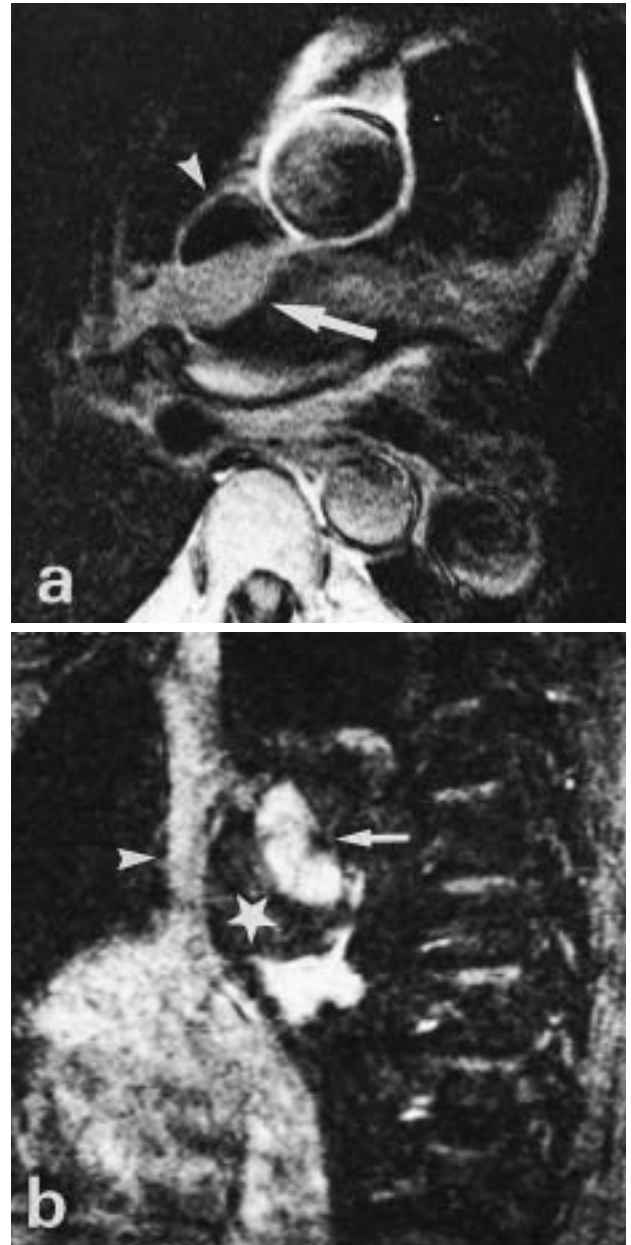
Pulmonary artery thrombosis. a) T1-weighted transverse image shows low-signal thrombus adjacent to the anterior vascular wall (arrow) with compression of the lumen of the superior vena cava (arrowhead). b) Parasagittal magnetic resonance-angiogram demonstrates nearly signal-void thrombus (star), high-signal true lumen of the enlarged right pulmonary artery (arrow), and medium-signal of the compressed superior vena cava (arrowhead).
